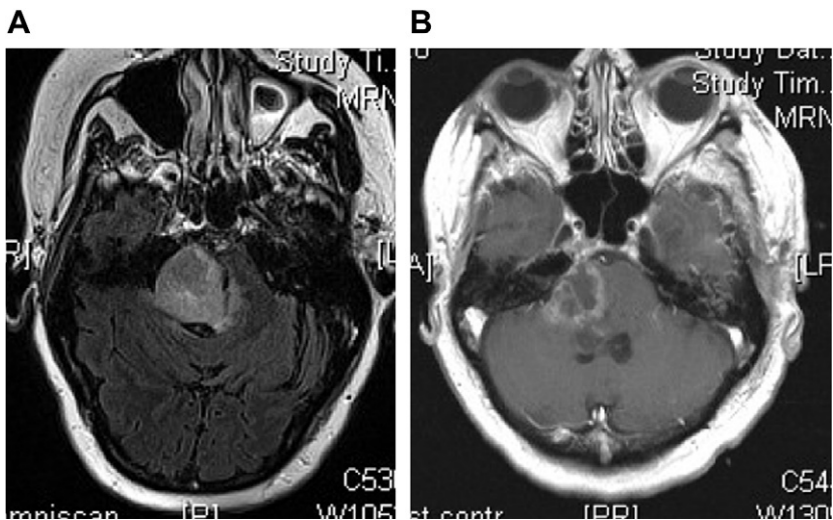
FLAIR (A) and gadolinium-enhanced T1-weighted (B) MRI images of a patient with facial numbness, peripheral facial weakness, and rapid obtundation owing to *Listeria monocytogenes* rhombencephalitis. Although diffuse cerebritis predominates in immunocompromised patients, previously healthy patients may have this characteristic focal brainstem parenchymal involvement.
